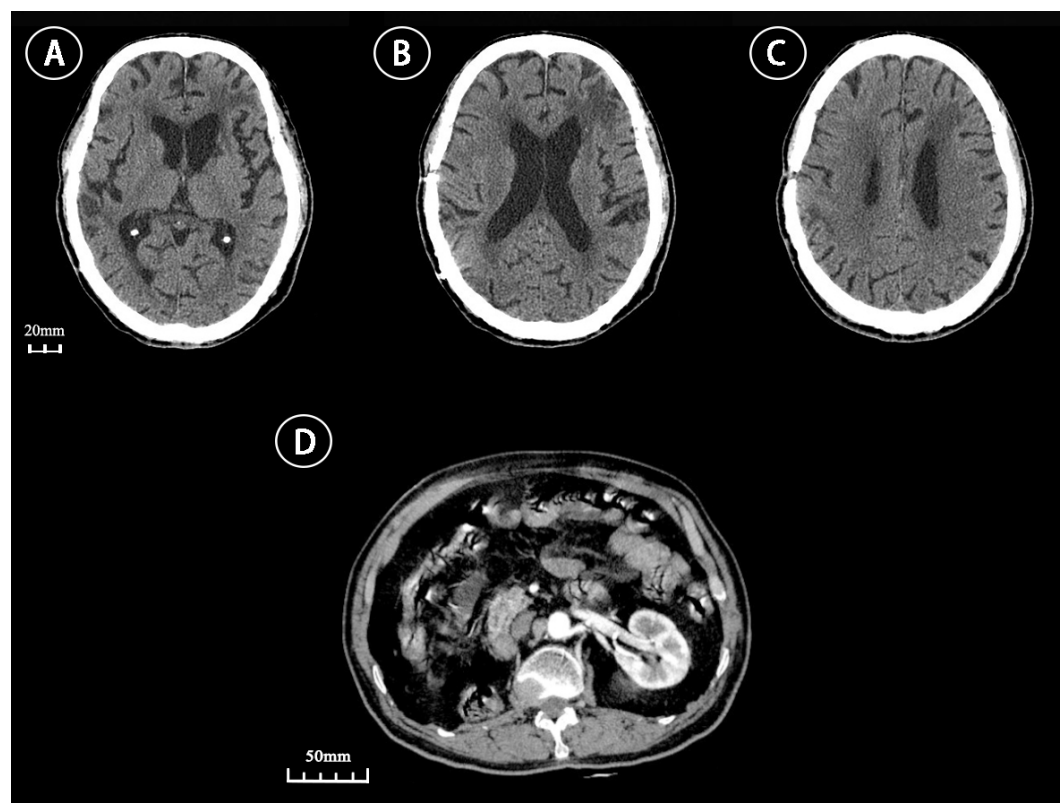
The most recent cranial CT images (A–C) showed a low-density shadow in the left frontal lobe, with improved edema compared to before treatment. The structure appeared centred, and there was no apparent compression of the ventricular system. There was no significant evidence of tumour recurrence. Abdominal enhanced CT showed no obvious signs of tumour recurrence (D).
